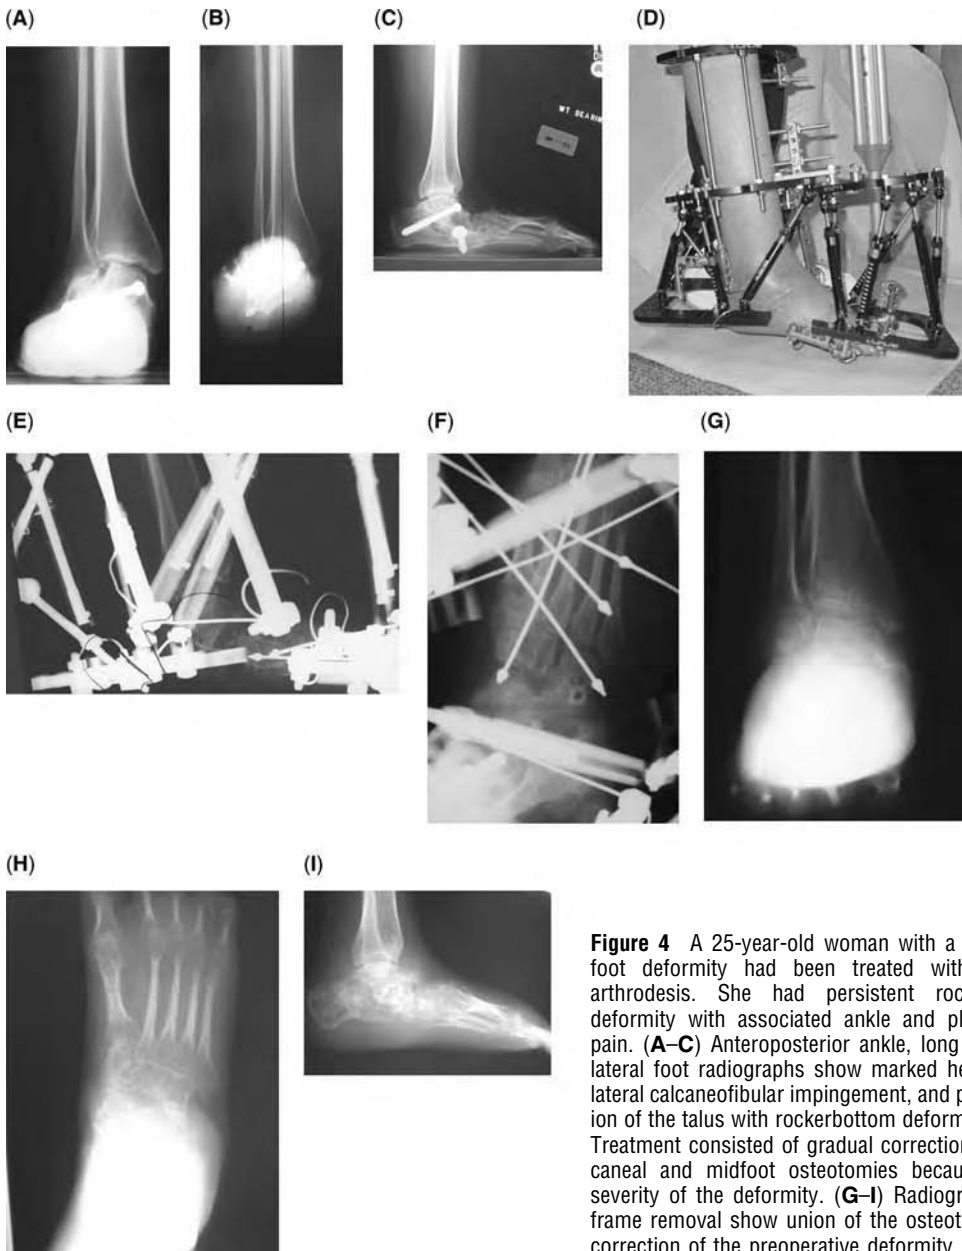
A 25-year-old woman with a congenital foot deformity had been treated with a triple arthrodesis. She had persistent rockerbottom deformity with associated ankle and plantar foot pain. (A–C) Anteroposterior ankle, long axial, and lateral foot radiographs show marked heel valgus, lateral calcaneofibular impingement, and plantarflexion of the talus with rockerbottom deformity. (D–F) Treatment consisted of gradual correction with calcaneal and midfoot osteotomies because of the severity of the deformity. (G–I) Radiographs after frame removal show union of the osteotomies and correction of the preoperative deformity.
